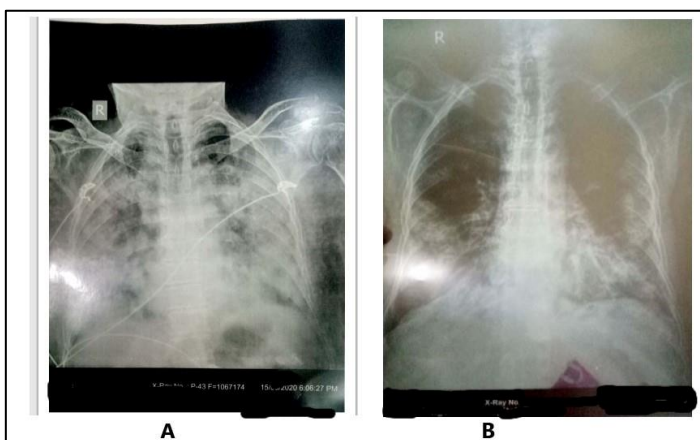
Comparative radiographs. A: X ray chest on day 3 of hospitalisation. B: X ray chest on day 10 of hospitalisation
